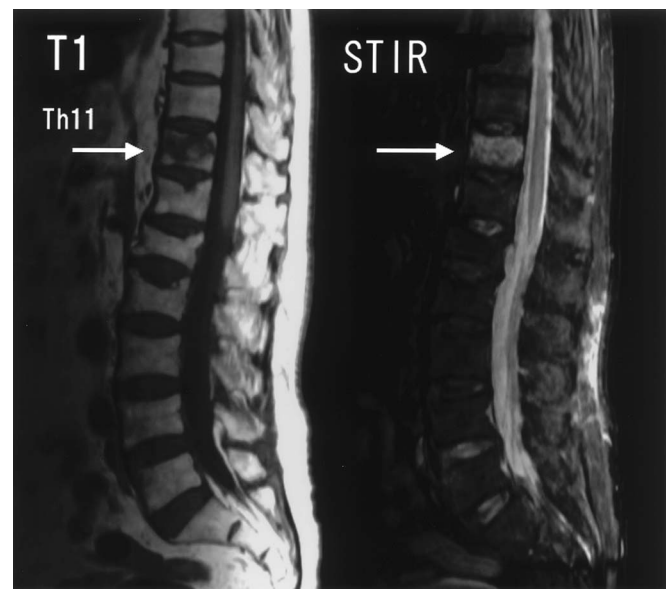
MRI scans. A T1-weighted scan (left) and fat-suppression scan (right) are shown. Because fresh compression fractures show high signal intensity (→) by fat-suppression imaging, this imaging is useful for the identification of the affected vertebrae.
